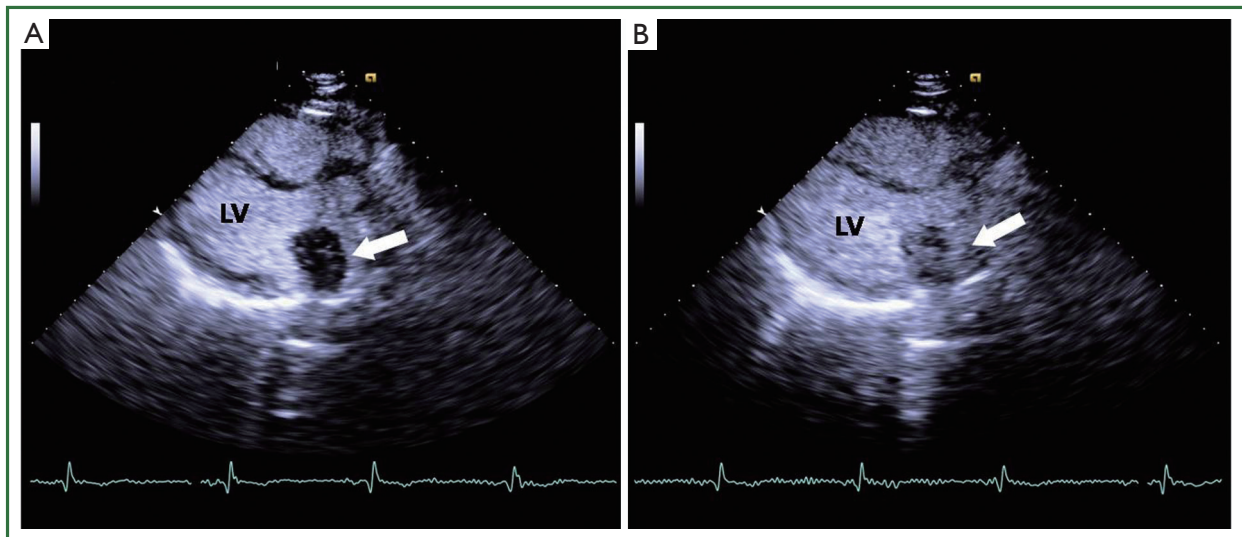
Contrast-enhanced echocardiographic image. (A) In the early phase, the mass was not enhanced; (B) In the late phase, the mass was enhanced. Abbreviation: LV, left ventricle.
